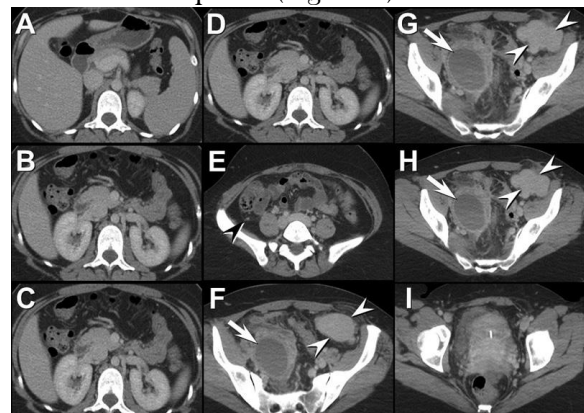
Representative images from axial enhanced abdominal CT scan. Click [here](#) to view Figure 3 in a separate, enlarged window.
